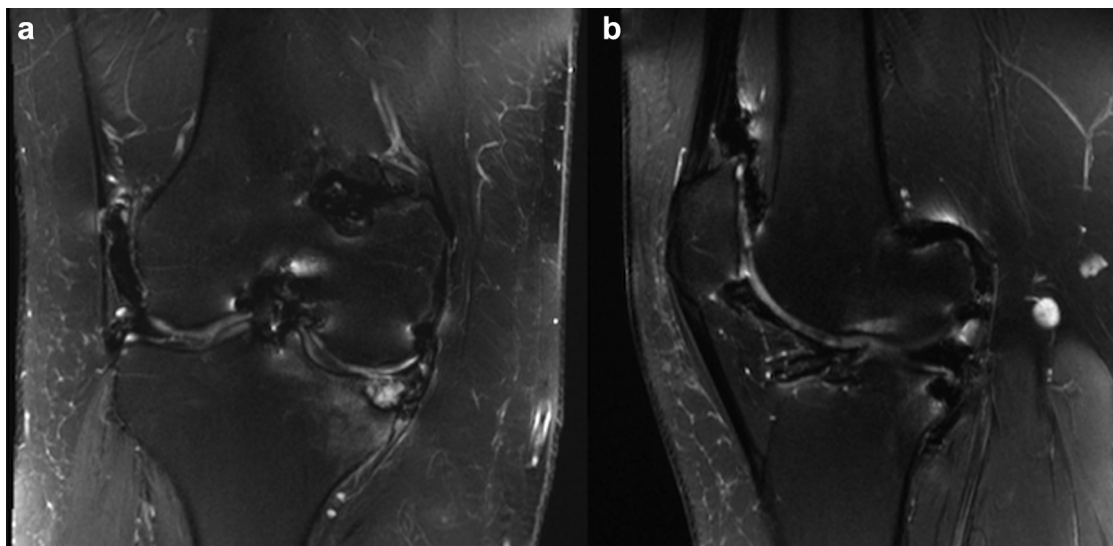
Coronal (a) and sagittal (b) fat-suppressed T2-weighted magnetic resonance images of the patient's right knee demonstrates hemosiderin deposition within the lining of the joint, extensive erosive changes in the posterior aspect of the femur and medial tibial plateau, and extensive tricompartmental osteoarthritis.
